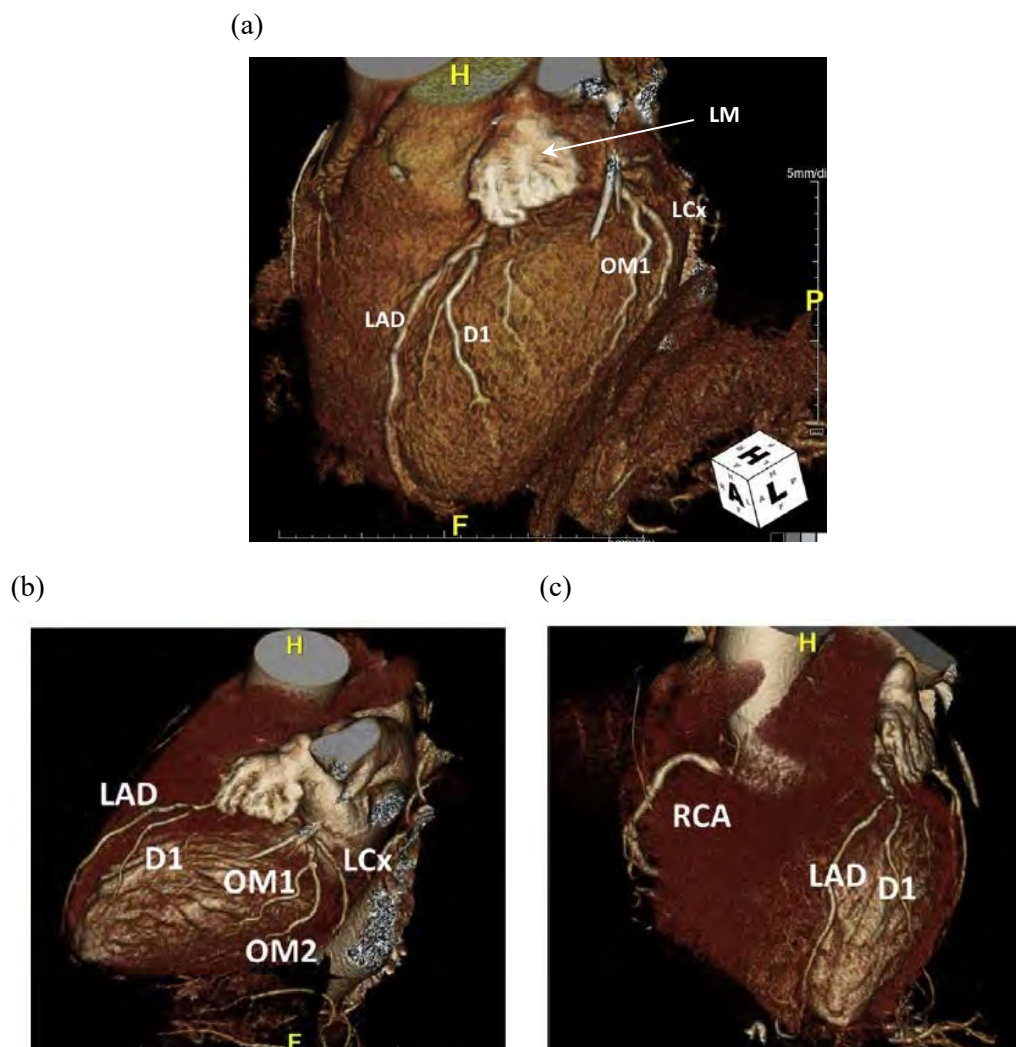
Computerised Tomography (CT) images showing different branches of the coronary arteries on the heart from different angles [2].
